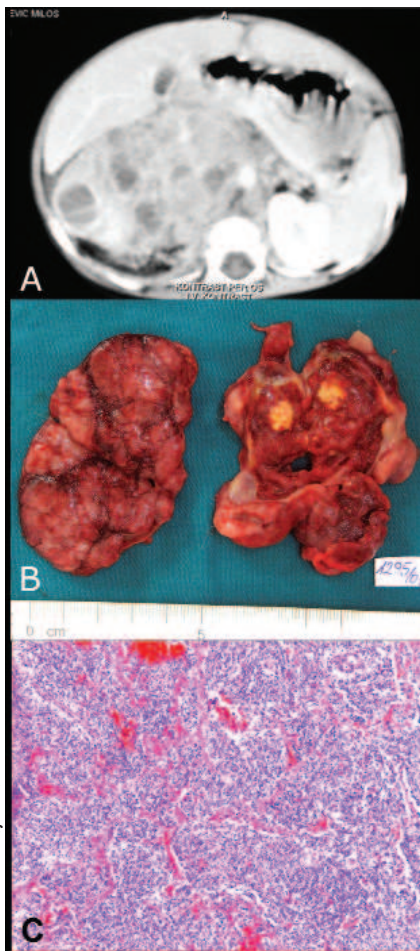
A large congenital neuroblastoma of the right adrenal gland. A. CT image with contrast emphasizes a lobular feature and heterogeneity of the tumour. B. Macroscopic feature of the lobular, encephaloid tumour mass. C.
